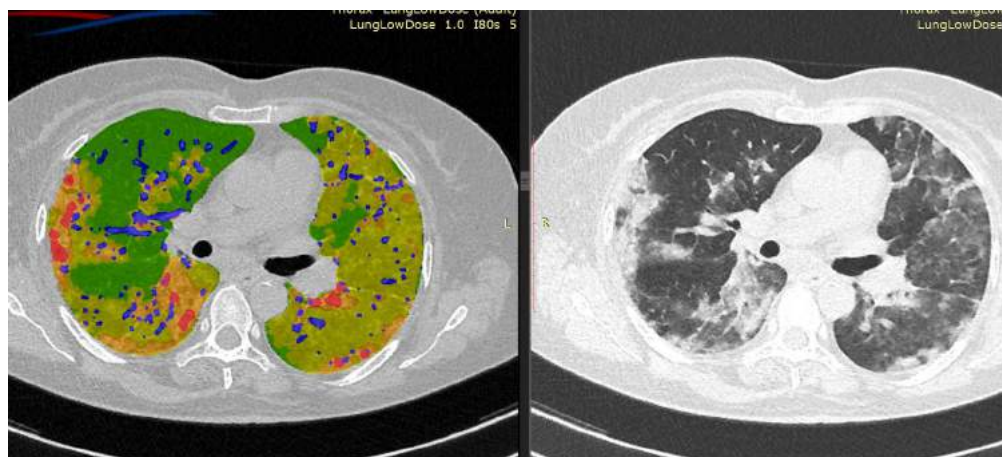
CT scan of lungs of a patient with COVID-19 pneumonia. Right side: native CT, lung window. Multiple areas of ground glass opacities, consolidation, and reticulation are seen in the both lungs. Visual grading of disease severity is difficult. Left image: the result of computer processing of CT dataset with dedicated software (MultiVox). Normal lung parenchyma is marked green, GGO, yellow, consolidation, orange and red and vessels are marked with blue.
